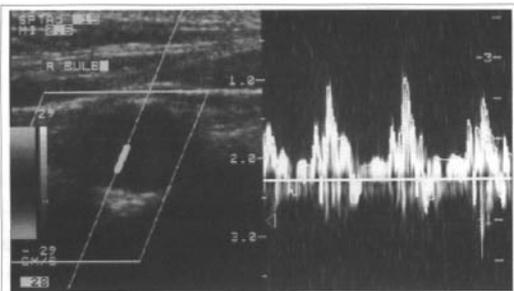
Flow separation in the internal carotid artery bulb. Doppler spectrum shows a complex low-frequency waveform with phases of reversed flow direction.
